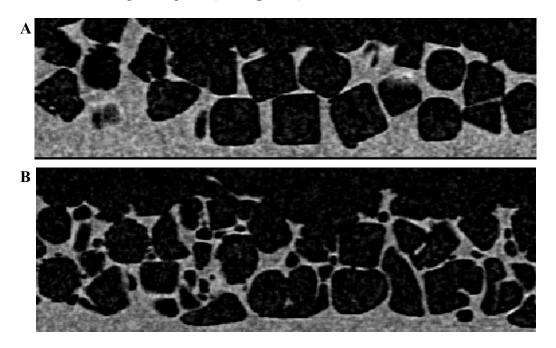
μ CT images of cervical spinal cage porous layers created by using A) Oven and B) Hot-press.
